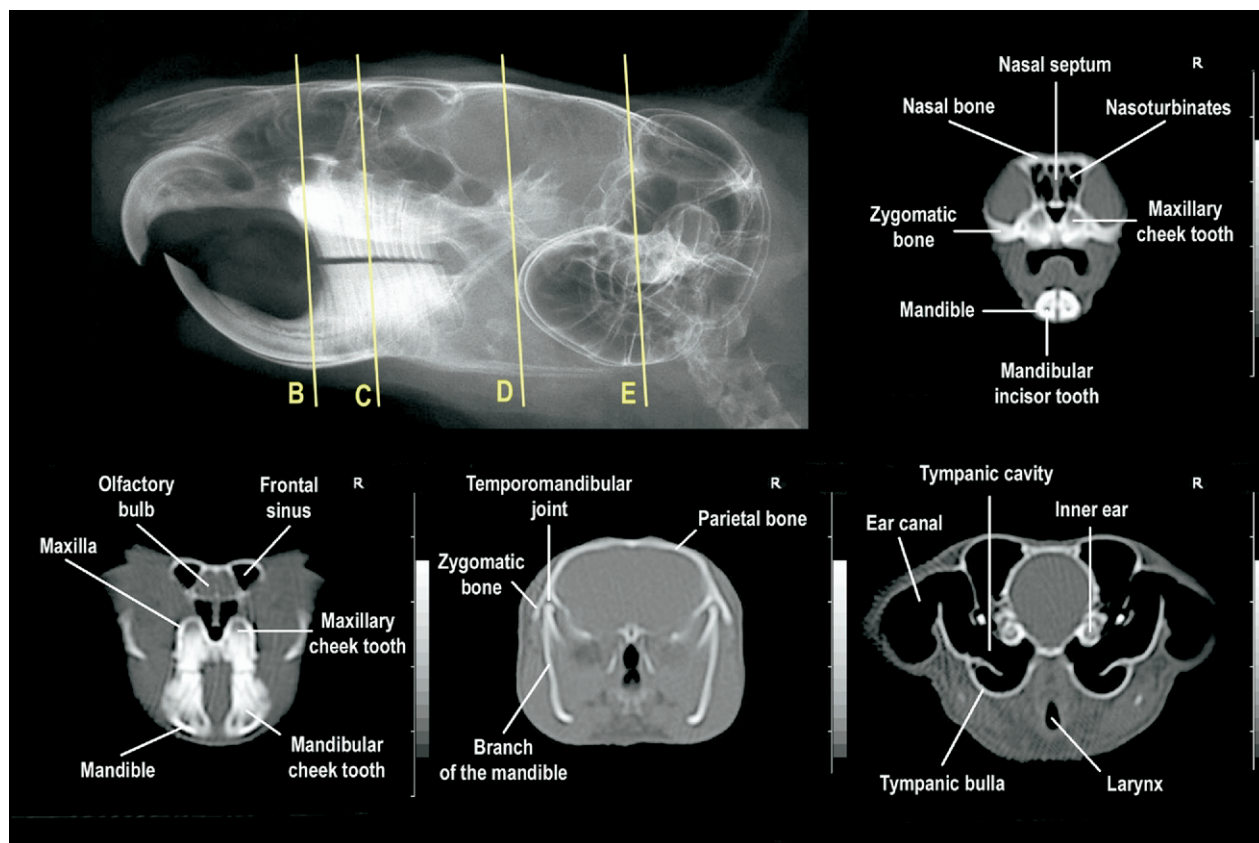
CT of the normal skull of a 500-g chinchilla. Scanning parameters: scan speed, 1 sec; mA, 125; kilovolt (peak), 120; slice thickness, 1 mm; reconstruction index, 0.5 mm; WL, 300; WW, 1500; image size (matrix), 512×512 pixels. The scout view demonstrating the scanning angles has been adapted from a radiograph of the normal skull for demonstration purposes. Reprint from: Capello V, Lennox A: Clinical Radiology of Exotic Companion Mammals. Wiley-Blackwell Publishing (2008), with permission.
